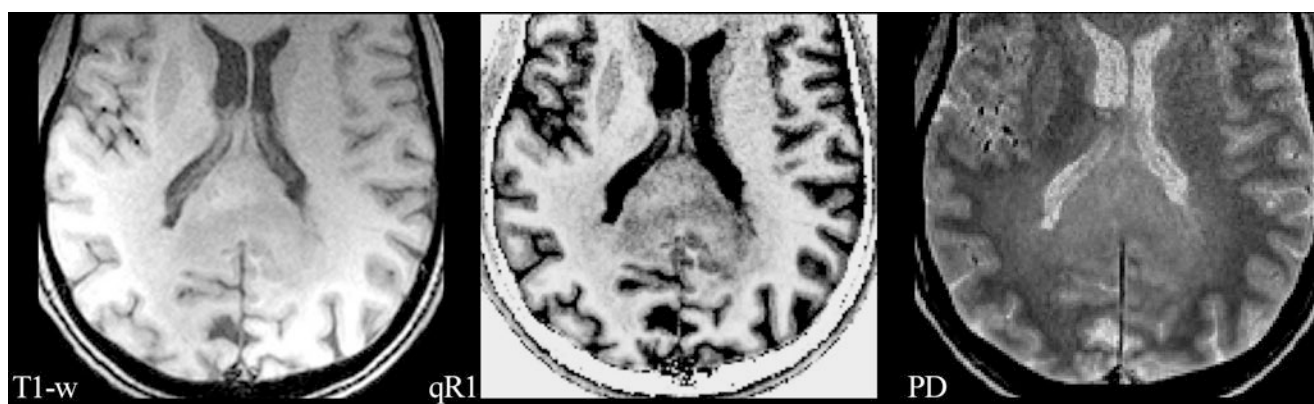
A glioblastoma of the splenium of the corpus callosum with adjacent subtle white matter changes which extended into both hemispheres and were suspicious for gliomatosis. Images from standard MRI (T1-w) and quantitative maps ($qR1$ and PD) are shown as in Fig. 1. T1 relaxation times of this infiltrative tumor are shorter compared to the glioblastoma in Fig. 1, resulting in a less hypointense appearance in $qR1$, while the PD is comparable. Thus, the tumor is hardly seen on
